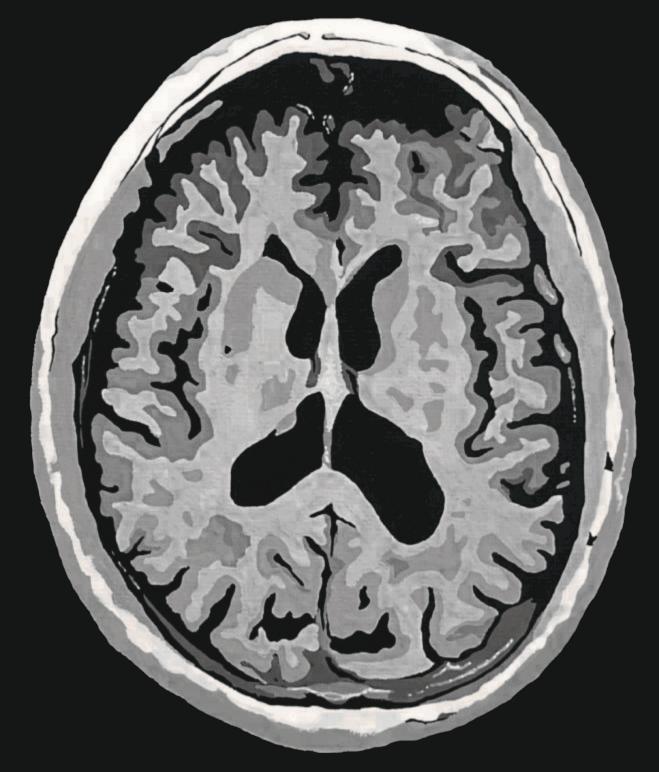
Affected brain MRI shows significant grey matter loss. A volume reduction of 26-27% in hippocampal regions and 38-40% in the entorhinal cortex is detected.1
